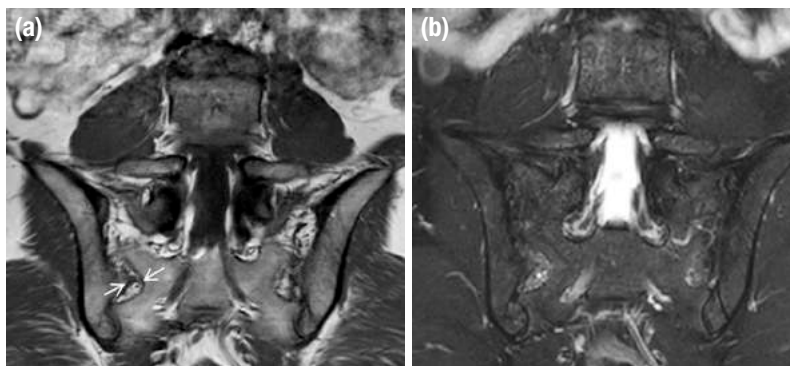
a, b. Iliosacral complex on the right side on MRI. Paracoronal T1W image (a) showed protrusion of the ilium and concave depression of the sacrum on the opposite (arrows). This region's vascular structures (asterisks) may mimic enthesitis on T1W FS post-contrast axial images (b).
